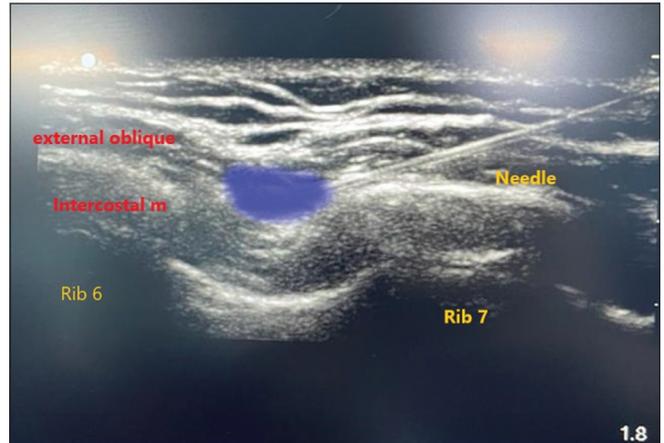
Ultrasound for external oblique intercostal block
